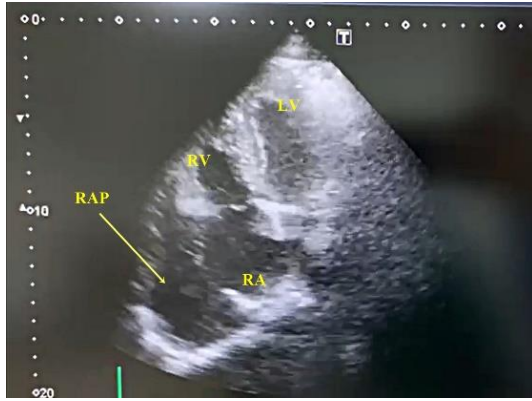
TTE, apical 4-chamber view; 87*40 mm large RA-related ruptured cystic cavity in the lateral aspect of the RA.
